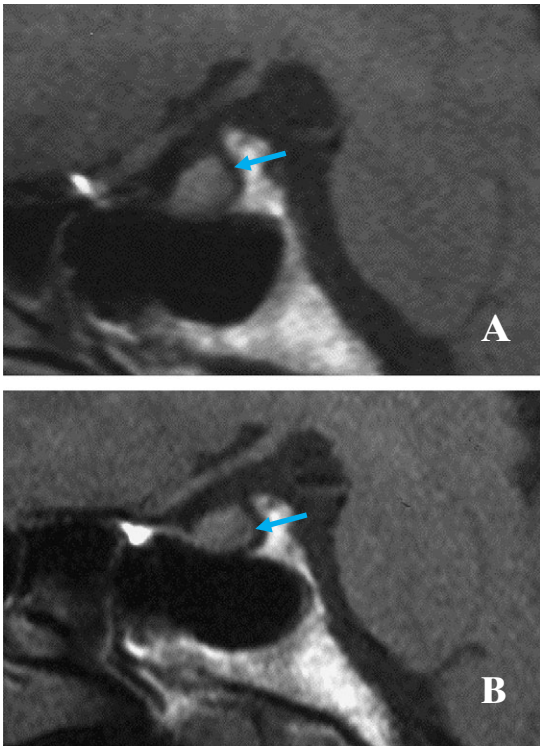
Sagittal section of T_1 -weighted MR-CT images of the pituitary gland before (A) and 4 months after (B) delivery
